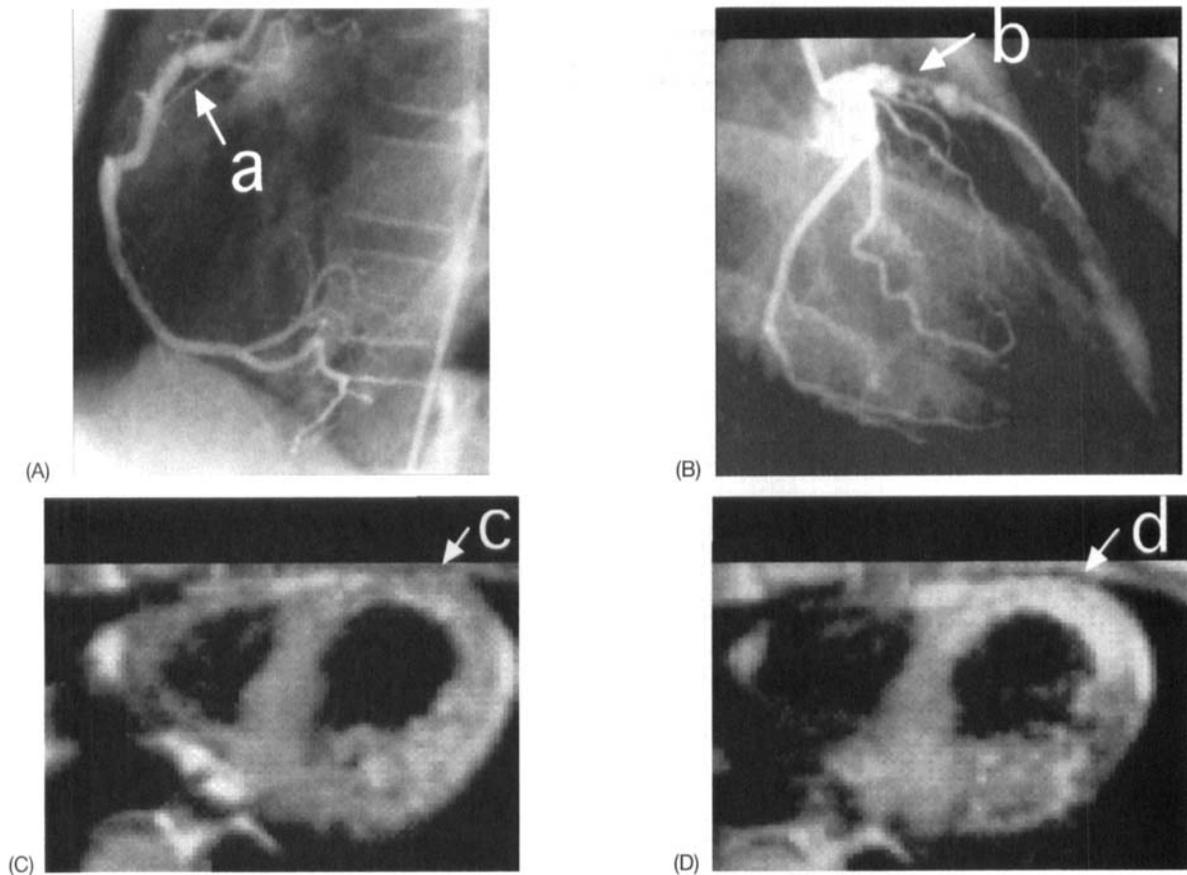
Case No. 3 (13-year-old girl): Coronary angiography at 10 years after diagnosis as old myocardial infarction (OMI) (A and B) and magnetic resonance imaging at 12 years after diagnosis of OMI (C and D). Localized stenosis is seen in the right coronary artery (arrow a), segmental stenosis is observed in the left anterior descending artery (arrow b). Thinning of the anterior wall is found (arrow c). After injection of gadolinium diethylenetriamine pentaacetic acid, enhancement is observed in the same region (arrow d).
